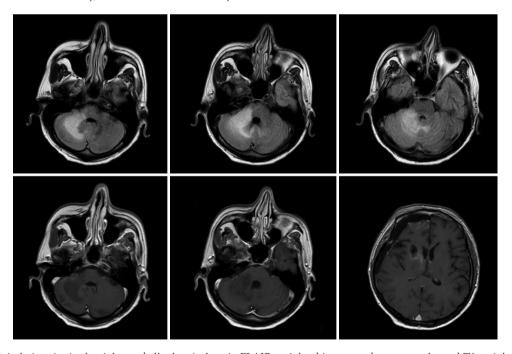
Growth in lesion size in the right cerebellar hemisphere in FLAIR-weighted images and contrast-enhanced T1-weighted images in patient 2 FLAIR: Fluid-attenuated inversion recovery
